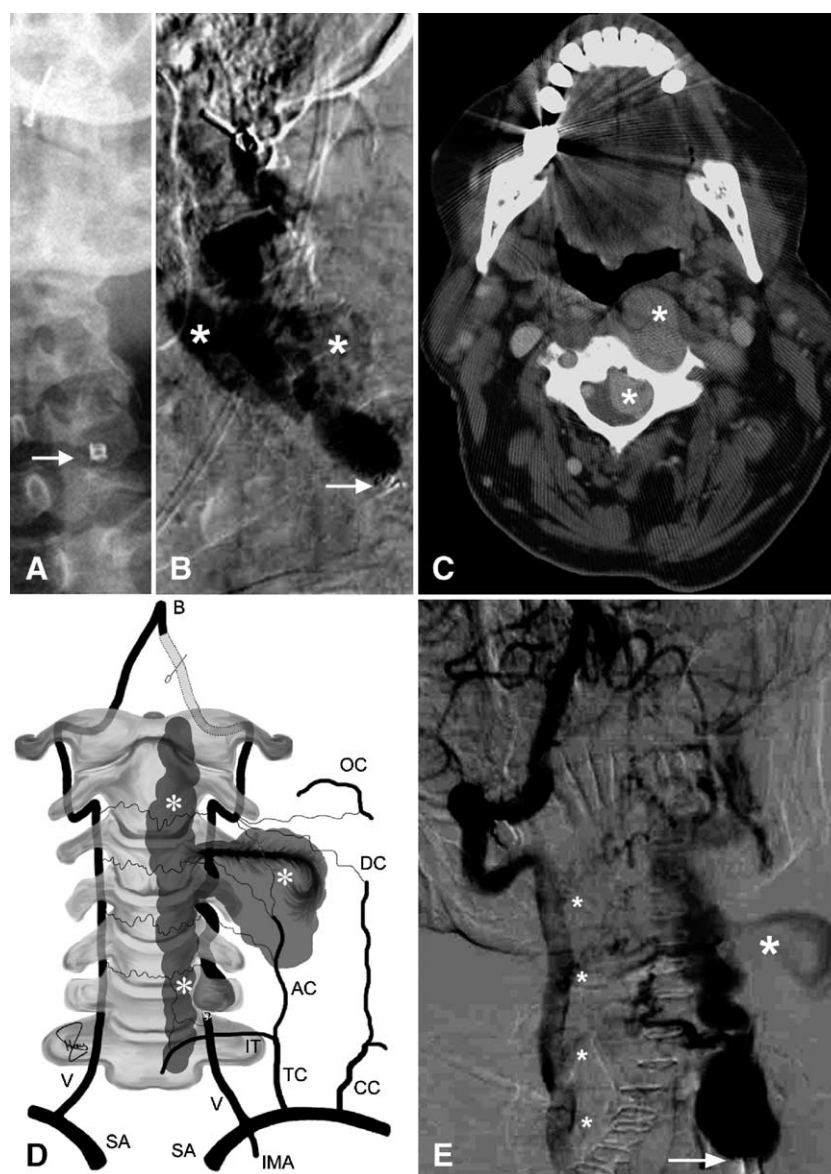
Imaging of a spontaneous vertebral AVF in NF-1. A: Ap plain x-ray demonstrating a clip placed at the foramen magnum level and a coil package at the C6/7 neural foramen (white arrow) in an attempt to trap a left vertebral artery (VA) fistula 18 years earlier. B: Digital subtraction angiogram, lateral view, shows maintained flow in the isolated segment of the left VA. Note the tortuous course of the VA ending in an aneurysmatic dilatation proximally just above the coil package (white arrow). The asterisks (\*) mark parts of the intra- and paraspinal varix. C: Contrast-enhanced CT of the C-spine at C3, the level of the fistula. Note bone scalloping at the left foramen transversarium and the large epidural intra- and paraspinal expansion of the varix (\*). Also note the mass effect with shift of the cord to the right. D: Artistic sketch summarizing the findings of superselective angiography and contrast-enhanced CT. The arteries are abbreviated as AC, ascending cervical; B, basilar; CC, costocervical trunk; DC, deep cervical; IMA, internal mammary; IT, inferior thyroid; OC, occipital; SA, subclavian; TC, thyrocervical trunk; and V, vertebral. Clip placement at the distal VA resulted in thrombus formation proximal and distal to the clip. The coil package occludes the left VA at C6/7. Several collaterals maintain flow in the “trapped” segment of the left VA and give the appearance of an AVM. However, the VA is the only direct feeder to the AVF. The varix extends intra- and paraspinally (\*). E: Ap view, digital subtraction angiogram. Maintained flow in the trapped left VA segment with partial thrombosis distally. Note the jet stream into the fistula at C3/4 (large asterisk). The vertebro-vertebral collaterals (small asterisk) indicate the spinal levels.
